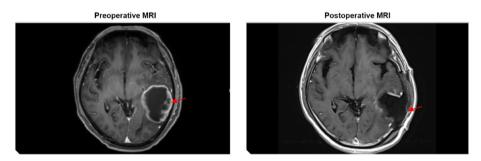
Comparison of brain MRI before and after operation. The red arrows indicate the tumor site.
